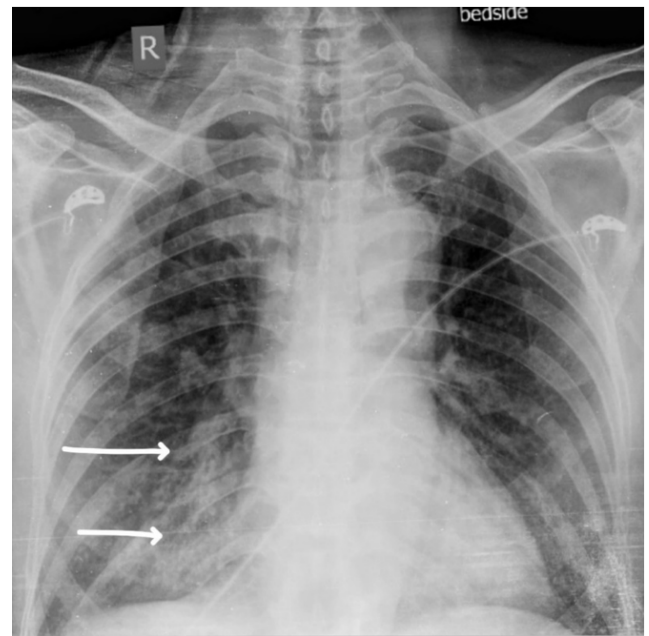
Chest X-ray follow up revealed significant infiltrates over right lower zone (white arrows). (Images taken from the department of radiology, KMCH)
